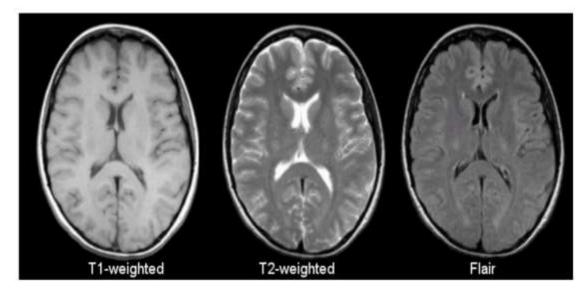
Types of MRI image sequences
